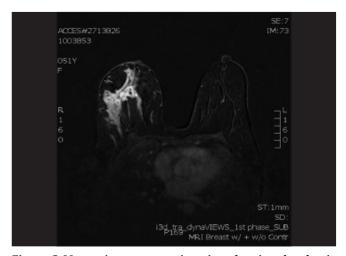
Magnetic resonance imaging showing dysplastic right breast tissue with focal ductal areas demonstrating contrast enhancement at the retro-areolar region
